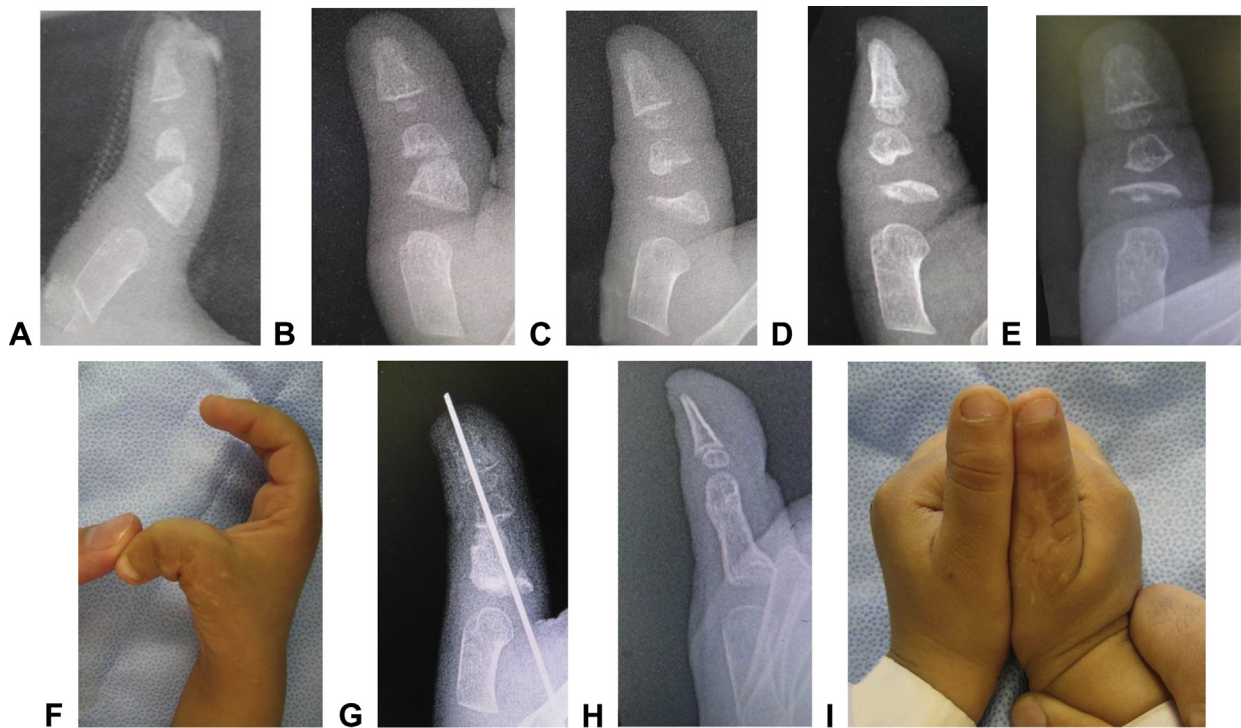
A X-ray at the time of injury. B X-ray at 3 months. There is nonunion and early resorption of the proximal fragment. C, D X-ray at 6 and 12 months, respectively, showing progressive resorption of the proximal fragment. E X-ray at 14 months (the time of presentation to the author). F Clinically, the thumb was flail. G The bone graft is fixed with a single K-wire. H, I Radiological and clinical appearance 20 months after the bone graft procedure.
